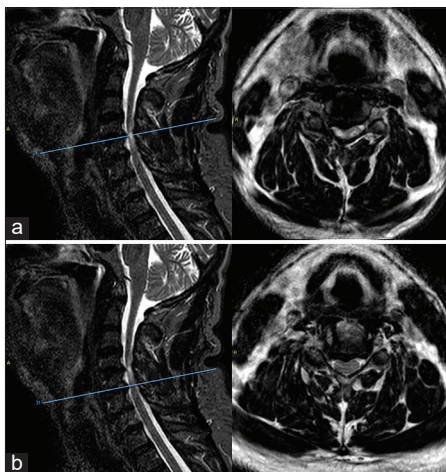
Sagittal (left) and axial (right) T2-weighted MRI sequences showing right paracentral disc herniation at C4–C5 (a) and C5–C6 (b) levels and myelopathy-associated spinal cord hyperintensity.
